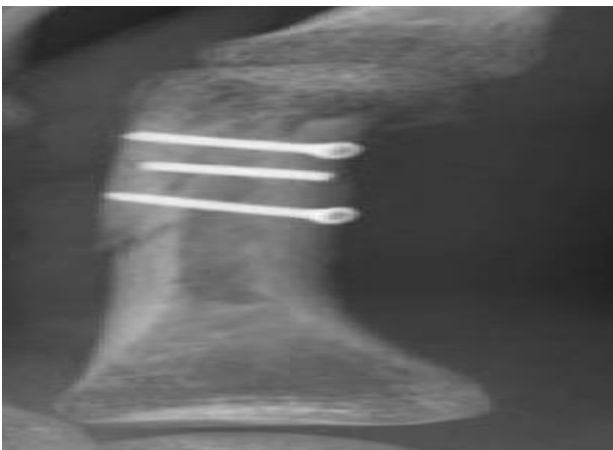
2 weeks post-operative oblique radiograph demonstrating maintained alignment and mild callus formation.
